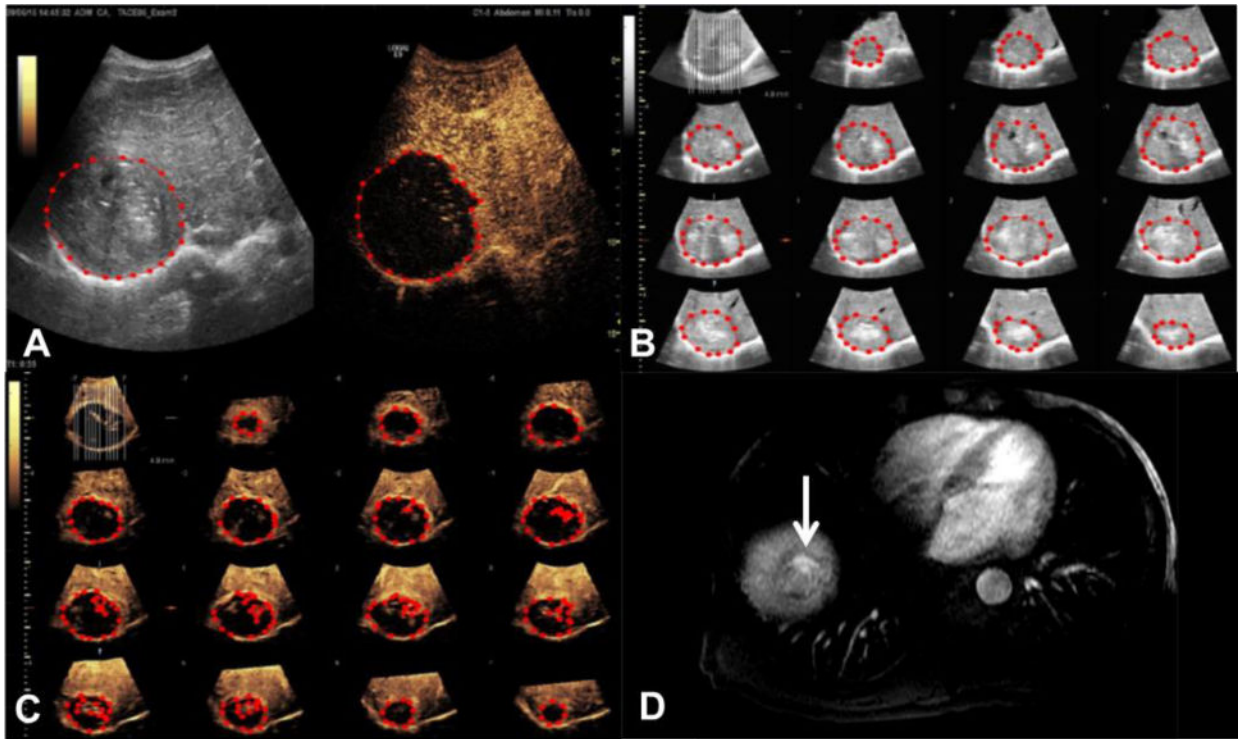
An example of residual tumor estimation – (A) 2D residual tumor estimate was calculated using the difference in tumor area on B-mode and non-enhanced intratumoral area on contrast-enhanced ultrasound, each outlined in red dashed line. 3D residual tumor estimate was calculated using the differences in tumor and non-enhancing intratumoral volumes, by adding 15 equidistant 2D areas across the tumor as outlined in red dashed lines, extracted from (B) B-mode volume and (C) contrast-enhanced ultrasound volume, respectively. (D) The residual tumor (arrow) was confirmed in magnetic resonance imaging 1 month post transarterial chemotherapy.
